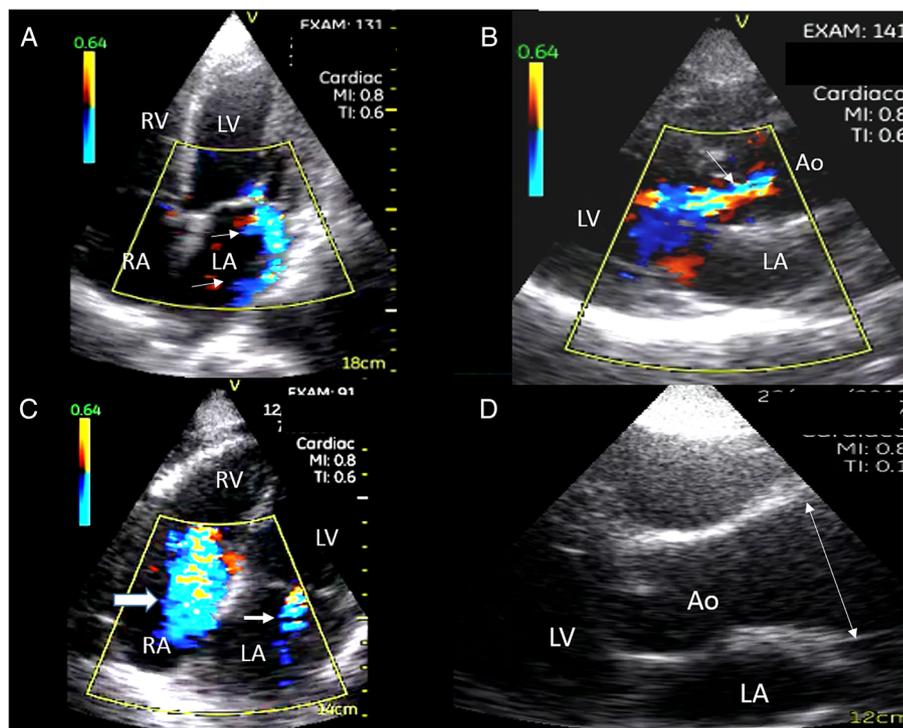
Hand-held cardiac ultrasound: (A) severe mitral valve regurgitation with Coanda effect (arrows) showed by colour Doppler in a four-chamber view; (B) severe aortic valve regurgitation visualised by parasternal long-axis view (arrow); (C) severe tricuspid valve regurgitation (large arrow) and mild mitral valve regurgitation (small arrow) in the apical four-chamber view; (D) ascending aorta enlargement in the upper part of the sinotubular junction (arrow) by parasternal long-axis view. LA: left atrium, LV: left ventricle, RV: right ventricle, Ao: ascending aorta, PE: pericardial effusion.
